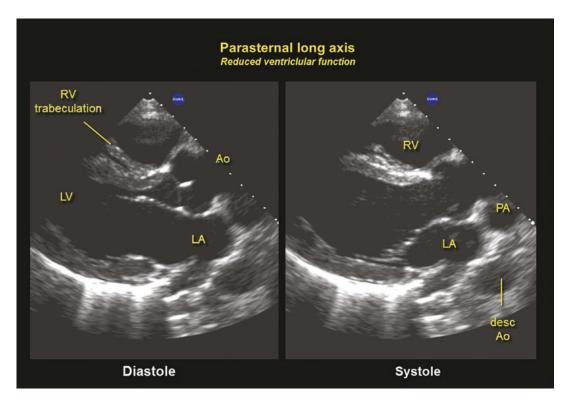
Parasternal long axis from a patient with a normal size left atrium. Note one of the main pulmonary artery branches (PA) on the top of the left atrium (LA). Compare this with Fig. 7.1
